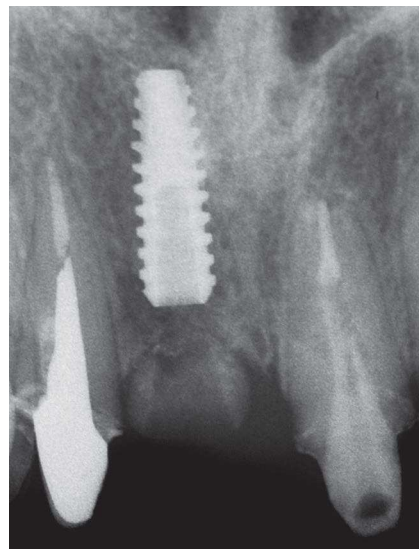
Periapical radiograph after conclusion of the clinical case.
